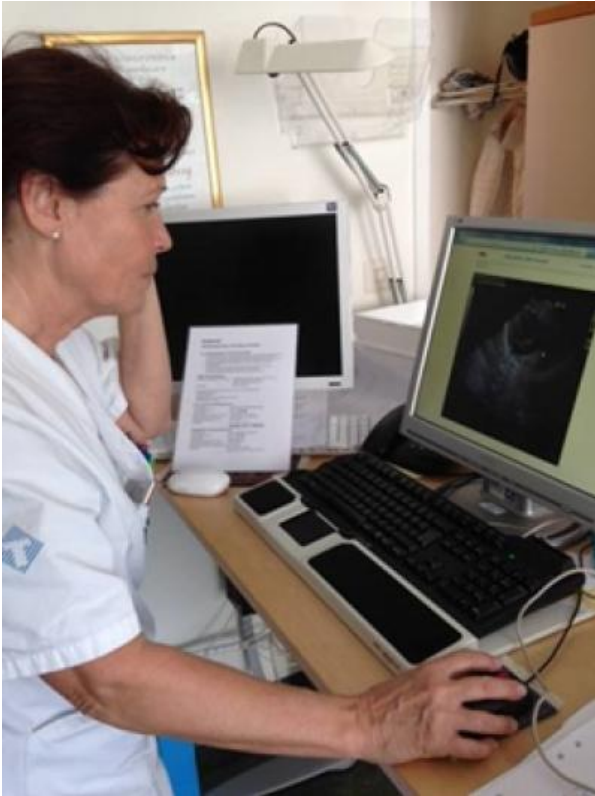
Examining ultrasound images of children with suspected heart conditions via secure web portal. (NTC 2017)
